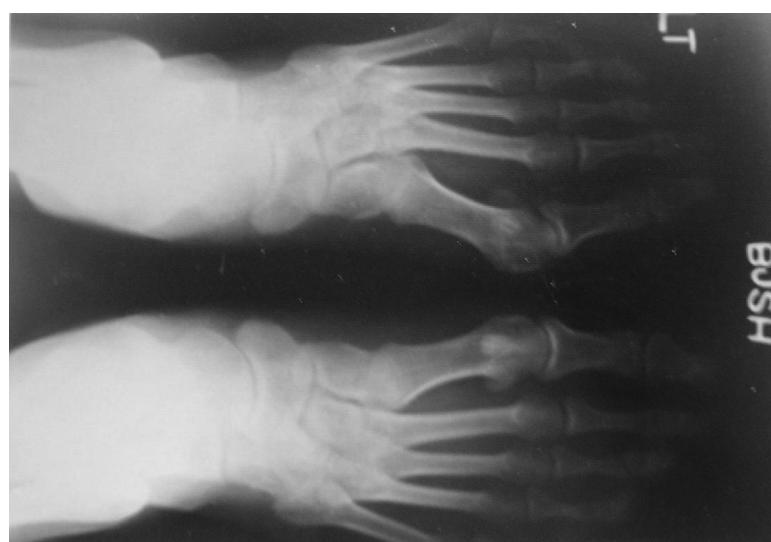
Radiograph showing the hallux valgus of the left foot
